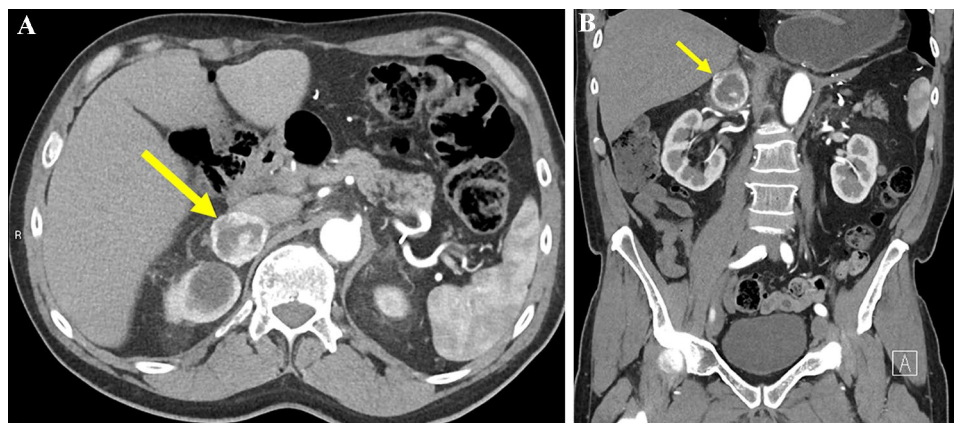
Axial (A) and coronal (B) arterial phase CT images showing a 4 cm heterogeneously enhancing right adrenal pheochromocytoma (arrow) with solid components demonstrating arterial and venous phase attenuation of 144 HU and 154 HU, respectively, and central areas of low attenuation due to necrosis and degeneration
